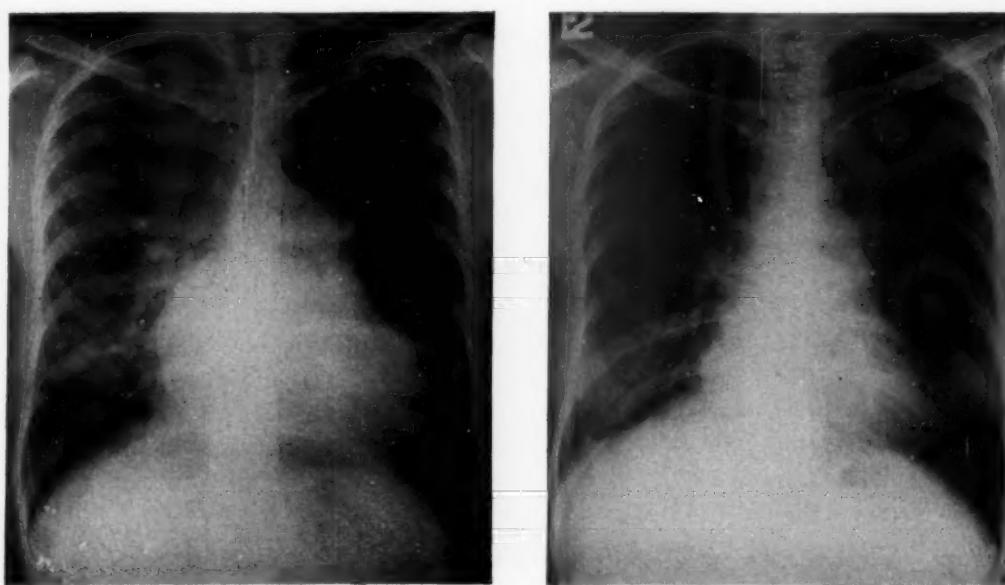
Anteroposterior roentgenograms before (A) and 3 months after (B) atrio-septo-pexy in patient H. W.
